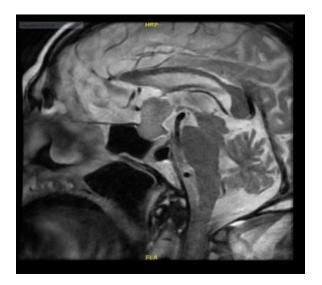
Magnetic Resonance Imaging (MRI) showing Diffuse Haemorrhages to the Pituitary Gland
